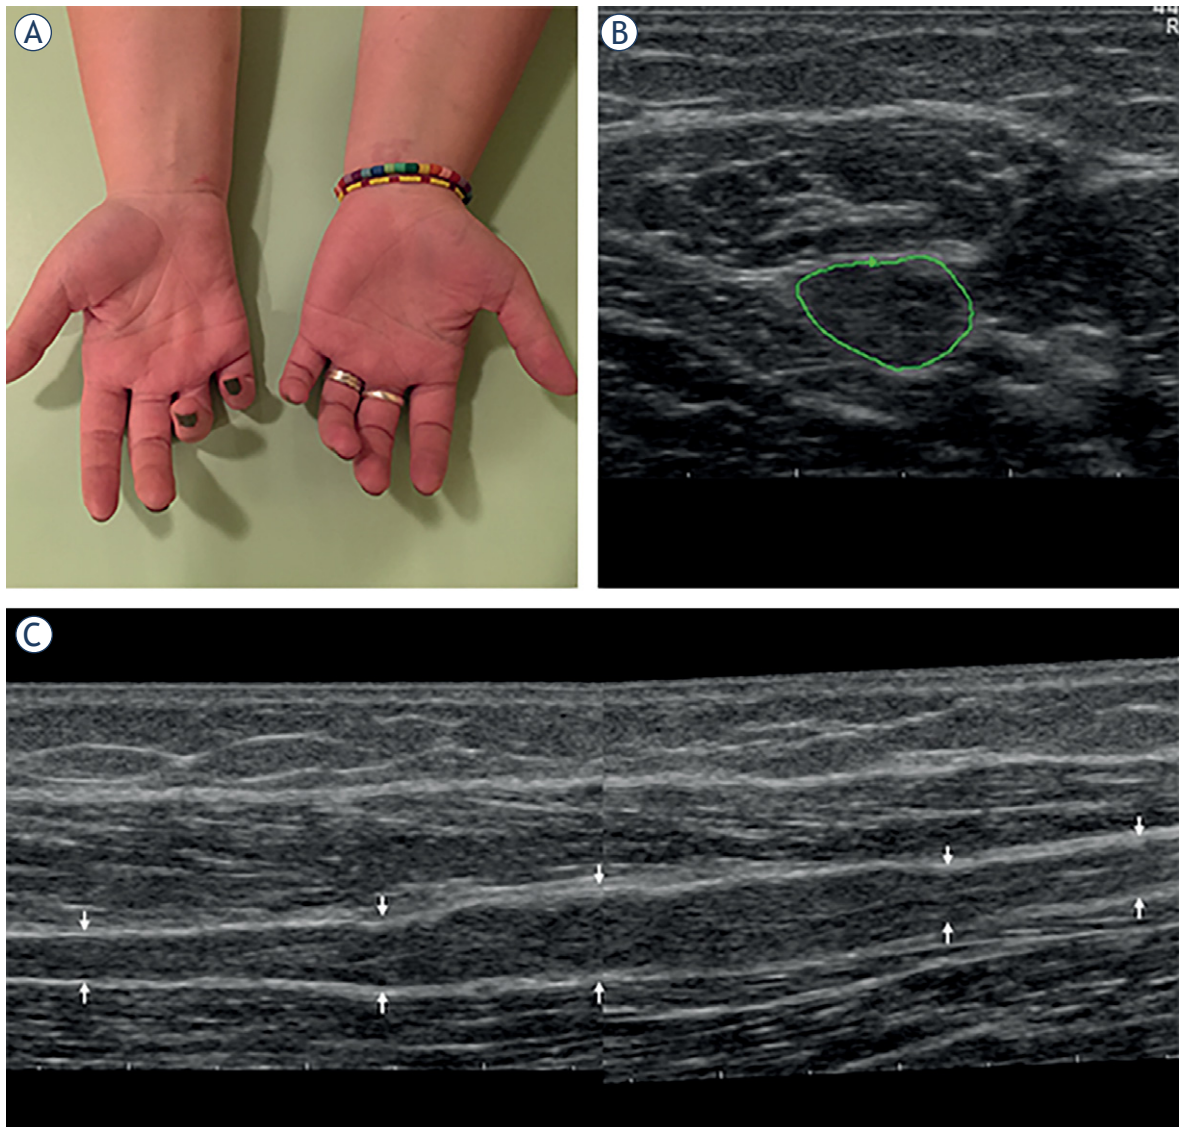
(A) Hands of a 26-year-old woman with 4-year history of muscle atrophy, weakness and numbness in the distal ulnar nerve territory (patient #5, Tables 2–3). Note intrinsic right palm muscle atrophy and clawing of the last two fingers. (B) On transverse ultrasonographic (US) view ulnar nerve cross sectional area (CSA) increased from 7 mm² both proximally and distally to 20 mm² in the middle of the lesion. (C) On longitudinal view a partially encapsulated, lobulated, fusiform hypoechoic right ulnar peripheral nerve tumour (PNT) of the forearm can be seen. Based on clinical and US features, we made a diagnosis of probable perineurioma.
